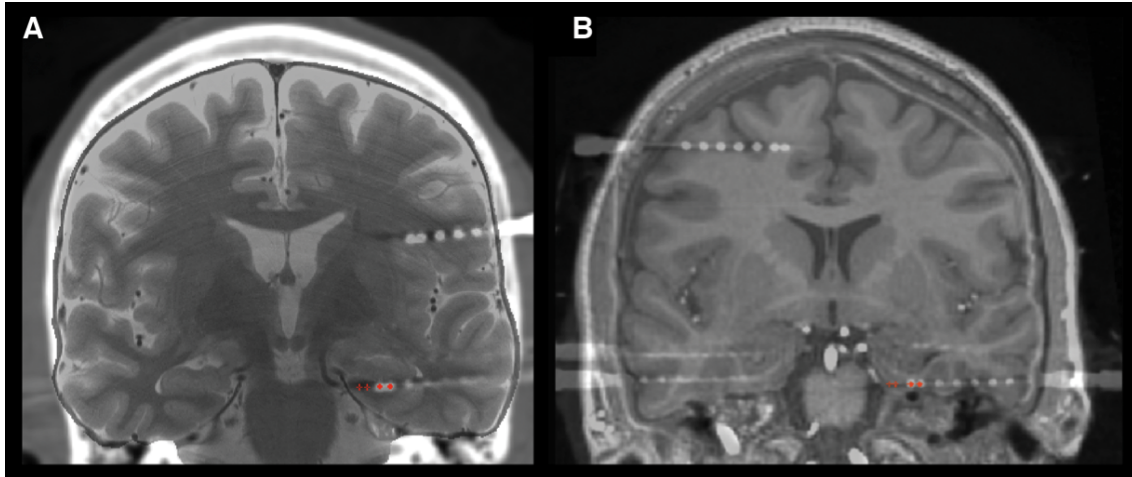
CO-REGISTERED MRI AND CT SCANS
